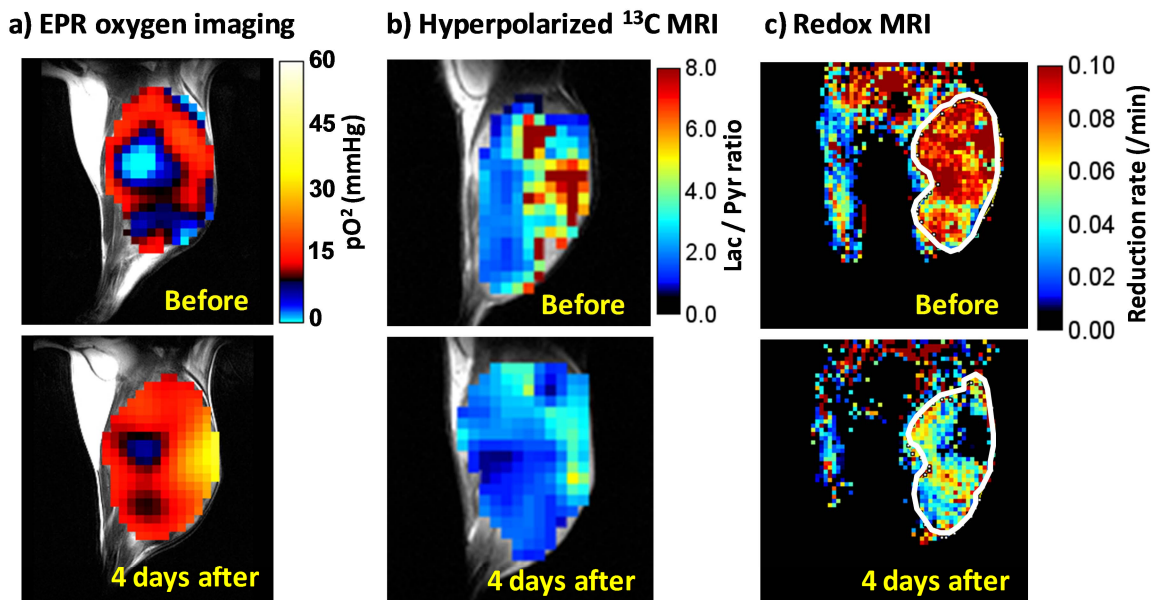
Anti-angiogenic treatment with sunitinib induced transient shift in tumor oxygenation by EPR imaging, energy metabolism by hyperpolarized ¹³C MRI of pyruvate metabolism, and redox state by MRI with nitroxide probe in SCCVII tumor.
